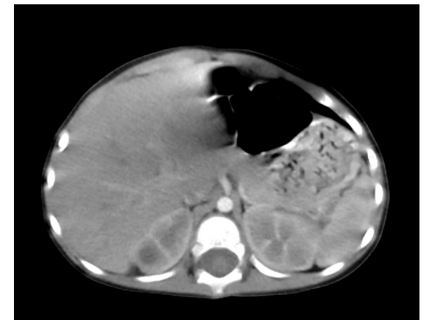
No liver cystic formation in the child's computed tomography images
